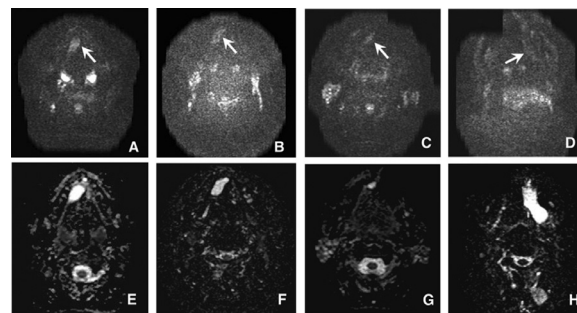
Differences of simple ranulas by sex and age on DWI (A, B, C, D) and in ADC values (E, F, G, H). DWI in a 13-year-old girl with a simple ranula (A), DWI in a 14-year-old boy with a simple ranula (B), DWI in a 54-year-old woman with a simple ranula (C), and DWI in a 52-year-old man with a simple ranula (D), all show well-defined masses confined to the sublingual space (arrow). The ADC map of a 13-year-old girl with a simple ranula (E, $2.82 \times 10^{-3} \text{ mm}^2/\text{s}$), the ADC map of an 11-year-old boy with a simple ranula (F, $2.36 \times 10^{-3} \text{ mm}^2/\text{s}$), the ADC map of a 54-year-old woman with a simple ranula (G, $2.94 \times 10^{-3} \text{ mm}^2/\text{s}$), and the ADC map of a 52-year-old man with a simple ranula (H, $2.45 \times 10^{-3} \text{ mm}^2/\text{s}$). *ADC*, apparent diffusion coefficient; *DWI*, diffusion-weighted imaging.
